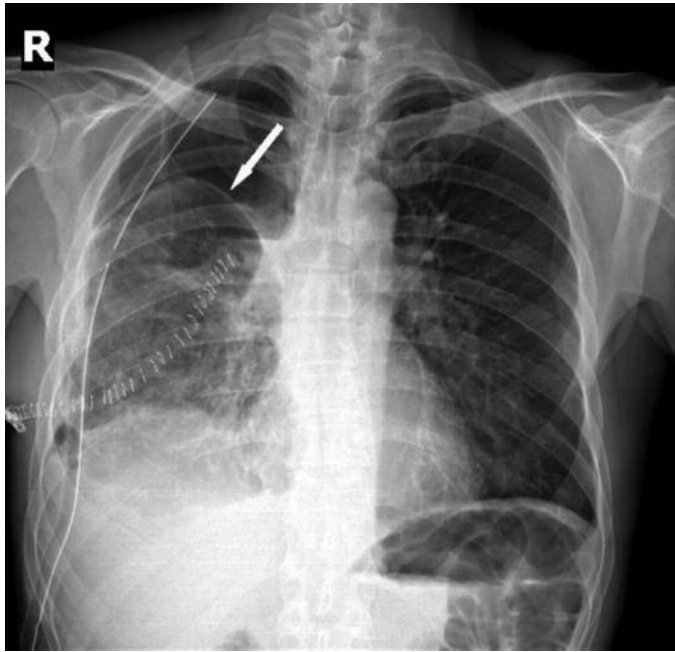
Chest X-ray before aseptic space. The patients have no parenchymal leaks, choosing the pathway of aseptic space. White arrow shows visceral pleural surface.
